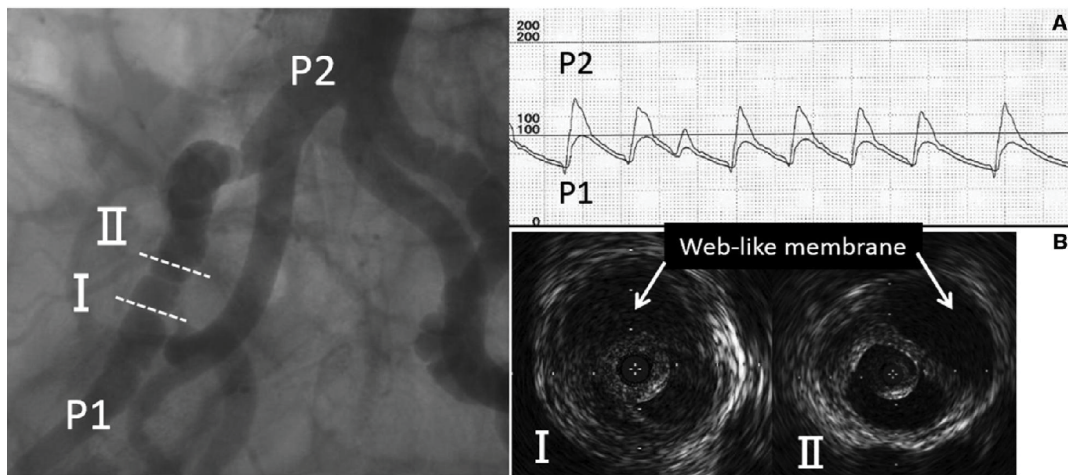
Pressure traces and intravascular ultrasound images (IVUS) of the right external iliac artery before balloon angioplasty were obtained using a 10 cm Radifocus sheath introducer inserted through the left brachial artery. Then, a 90 cm Destination guiding sheath was exchanged and advanced into the right common iliac artery. Once 175 cm of the 0.014 inch Cruise guide wire was positioned proximal to the string of beads pattern of the right iliac artery, IVUS was utilized to locate the web-like membrane obstructing the lumen. Given the multiple sites of stenosis, the pressure gradient across the FMD lesion was measured using a 0.014-inch Aeriis pressure wire [15]. A) Pre-angioplasty pressure gradient across the lesion depicting a peak value of 45 mmHg [15]; B) Web-like membrane evident in the lumen before angioplasty [15].
